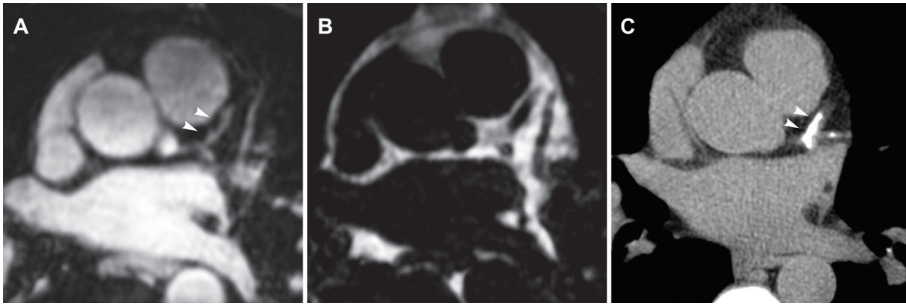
Example of respiratory navigator-gated 3D whole-heart coronary dual-echo Dixon gradient echo (GRE) imaging with water-fat separation: a 57-year-old man with familial hypercholesterolemia and a positive family history for coronary artery disease. (A) Transverse Dixon water-image. (B) Transverse Dixon fat-image. (C) CT image for calcium scoring. Note the severe calcification (arrows) in the left main (LM) coronary artery and proximal left anterior descending (LAD) and left circumflex coronary artery, corresponding to the dark areas on the water-fat resolved Dixon coronary MRA images (arrows).
